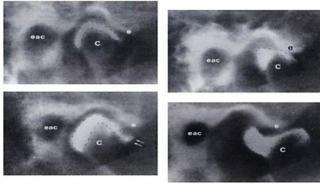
Radiographic images of TMJ seen in arthrography (C-Condyle; EAC – E- External auditory canal)
